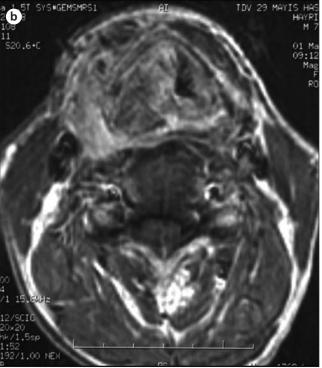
Sagittal (a) and transverse (b), T1 and T2 weighted MRI scans with contrast showed an infiltrative mass which filled up rigth hypopharynx and larynx.
